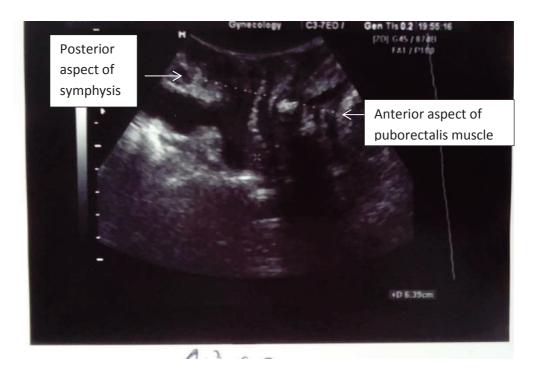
Measurement of the LH by means of two-dimensional ultrasound.
